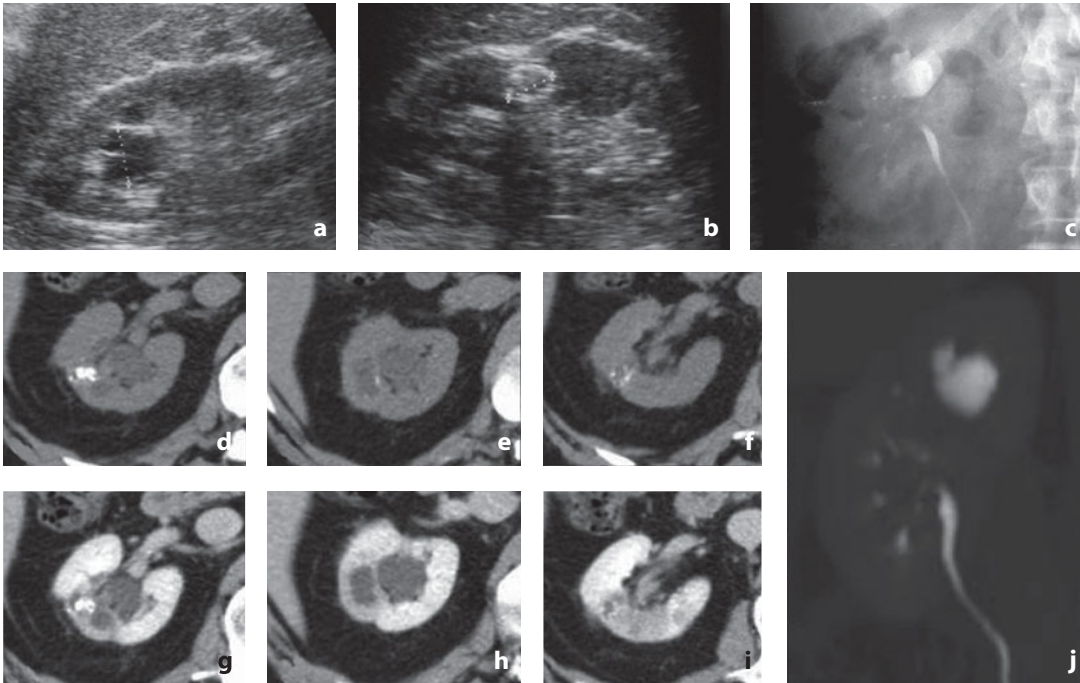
Ultrasonography, urography and CT. Renal tuberculosis. a US study shows a bilobular and probably fluid-filled hypoechoic area in the superior sinus and b a nodular calcification associated with parenchymal thinning in the mid-third of the kidney, without signs of hydronephrosis. c At urography a cavitory image in the superior sinus corresponding to the US findings, and stenosis of the major calices and pelvis. d-f Nonenhanced CT images show reduced parenchymal thickness at the mid-upper third of the kidney associated with parenchymal calcifications and hypoattenuating areas in the parenchyma. g-i In the same planes after contrast medium injection the cavitations in the parenchyma are appreciable. j Coronal reconstruction of the images acquired in the excretory phase shows the amputated calyx of the superior system and the proximal cavity
